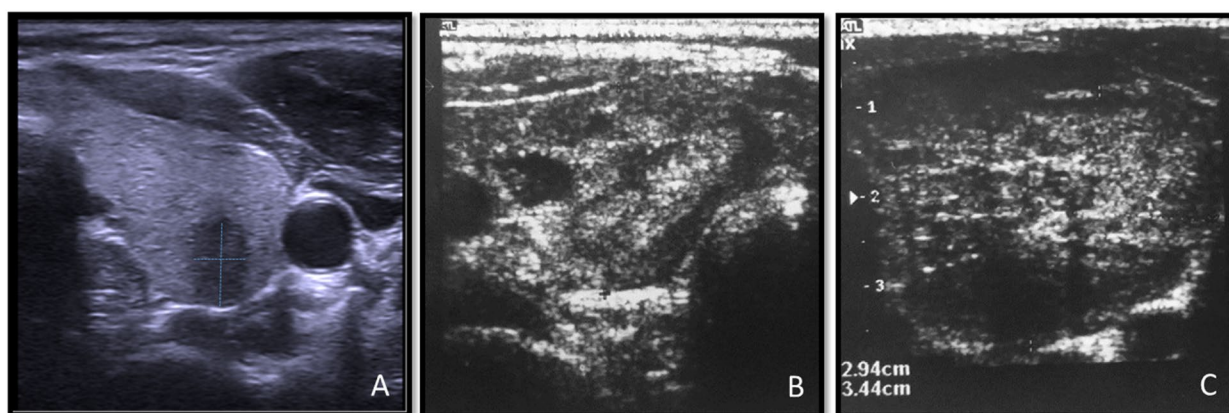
Different sonographic patterns of thyroid nodules. TR5: A Completely solid nodule, hypoechoic, taller than wide. B Complex hypoechoic nodule with echogenic foci. C Very hypoechoic nodule with irregular border, punctate multiple echogenic foci
